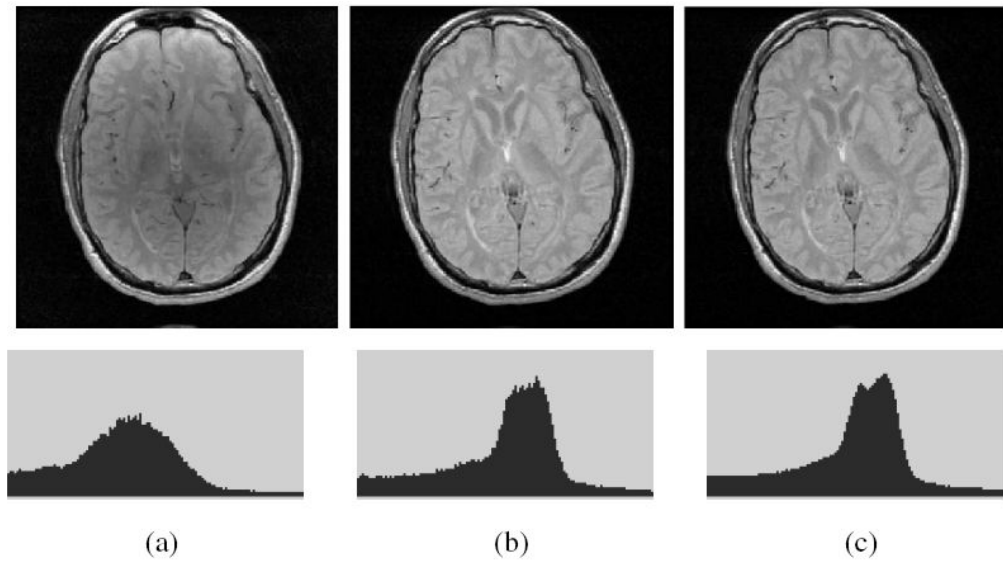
(a) A slice of a MRI PD scene of the head of a patient with Multiple Sclerosis. The corresponding slice of the corrected scene output by (b) *N3*, and (c) *SBC* methods, and the respective histograms (bottom).
